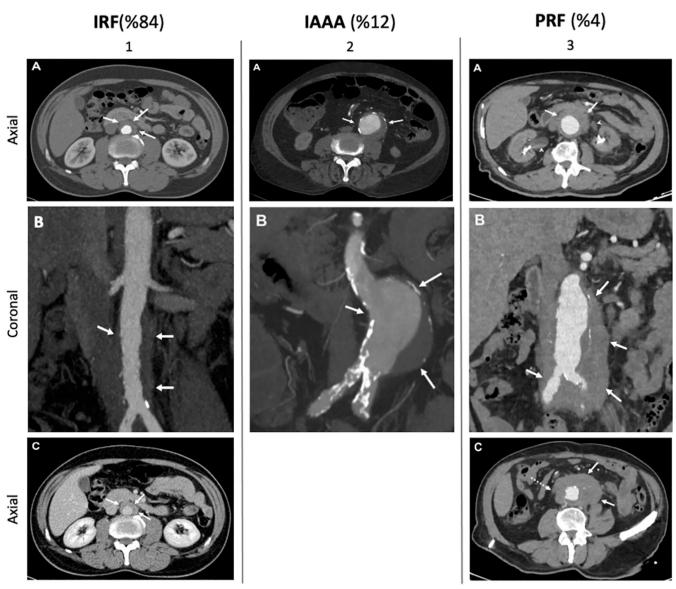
Types of chronic periaortitis. 1-A. Axial arterial phase contrast-enhanced CT image shows periaortic soft tissue thickening around the infrarenal abdominal aorta (arrows). 1-B. Coronal reformatted MIP (maximum intensity projection) image demonstrates aortic wall irregularity and periaortic soft tissue thickening (arrows). 1-C. Axial CT image obtained in venous phase shows contrast enhancement in perioartic soft tissue (arrows). 2-A. Axial arterial phase contrast-enhanced CT image shows a partially thrombosed infrarenal abdominal aortic aneurysm (arrows). 2-B. Coronal reformatted MIP (maximum intensity projection) image better delineates the craniocaudal extension of aortic aneurysm (arrows). 3-A. Axial arterial phase contrast-enhanced CT image shows periaortic mass-like soft tissue thickening around the abdominal aorta (arrows). Also, bilateral hydroureteronephrosis (arrowheads) and bilateral nephrostomy catheters are observed. 3-B. Coronal multiplanar reconstructed (MPR) image demonstrates the periaortic soft tissue surrounding the aorta and both common iliac arteries (arrows). Accompanying partially thrombosed aortic aneurysm is also seen. 3-C. Axial CT image shows that the right ureter (dashed arrow) is retracted medially into the perioartic soft tissue (arrows).
